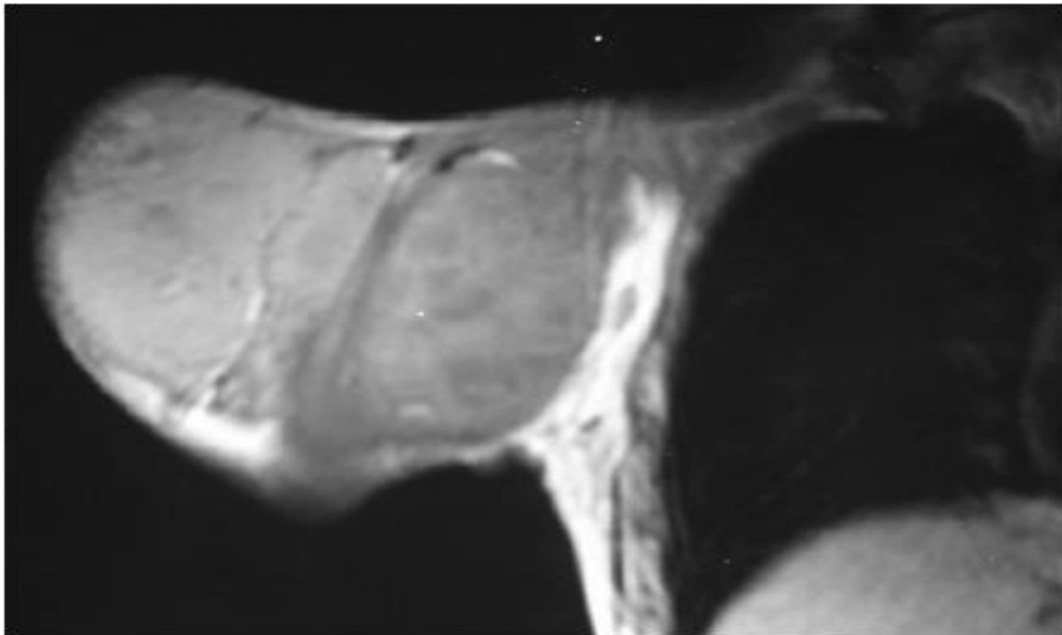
MRI of his right shoulder revealed large soft tissue tumor mass with neurovascular bundle lying in the tumor.
